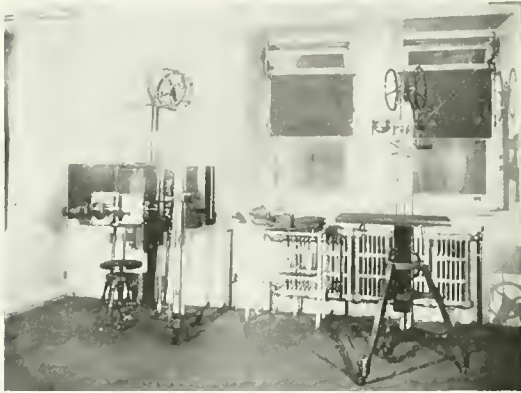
Another view of the general roentgenographic room.
